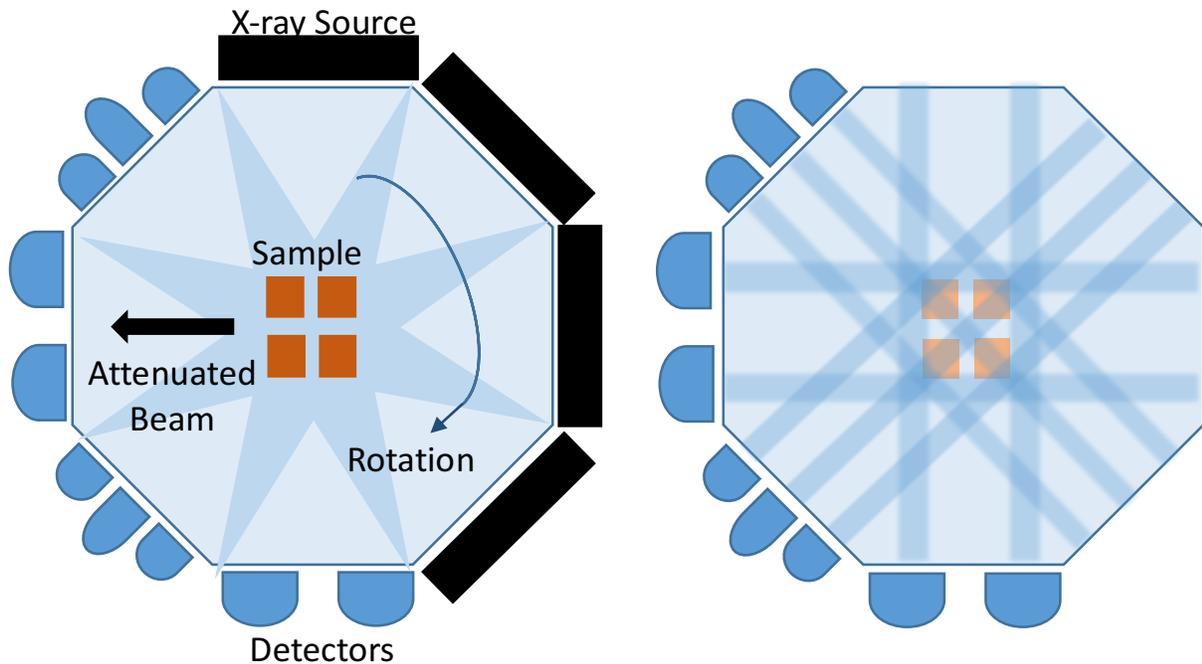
Set-up of X-ray CT scans, imaged at incremental projection angles
